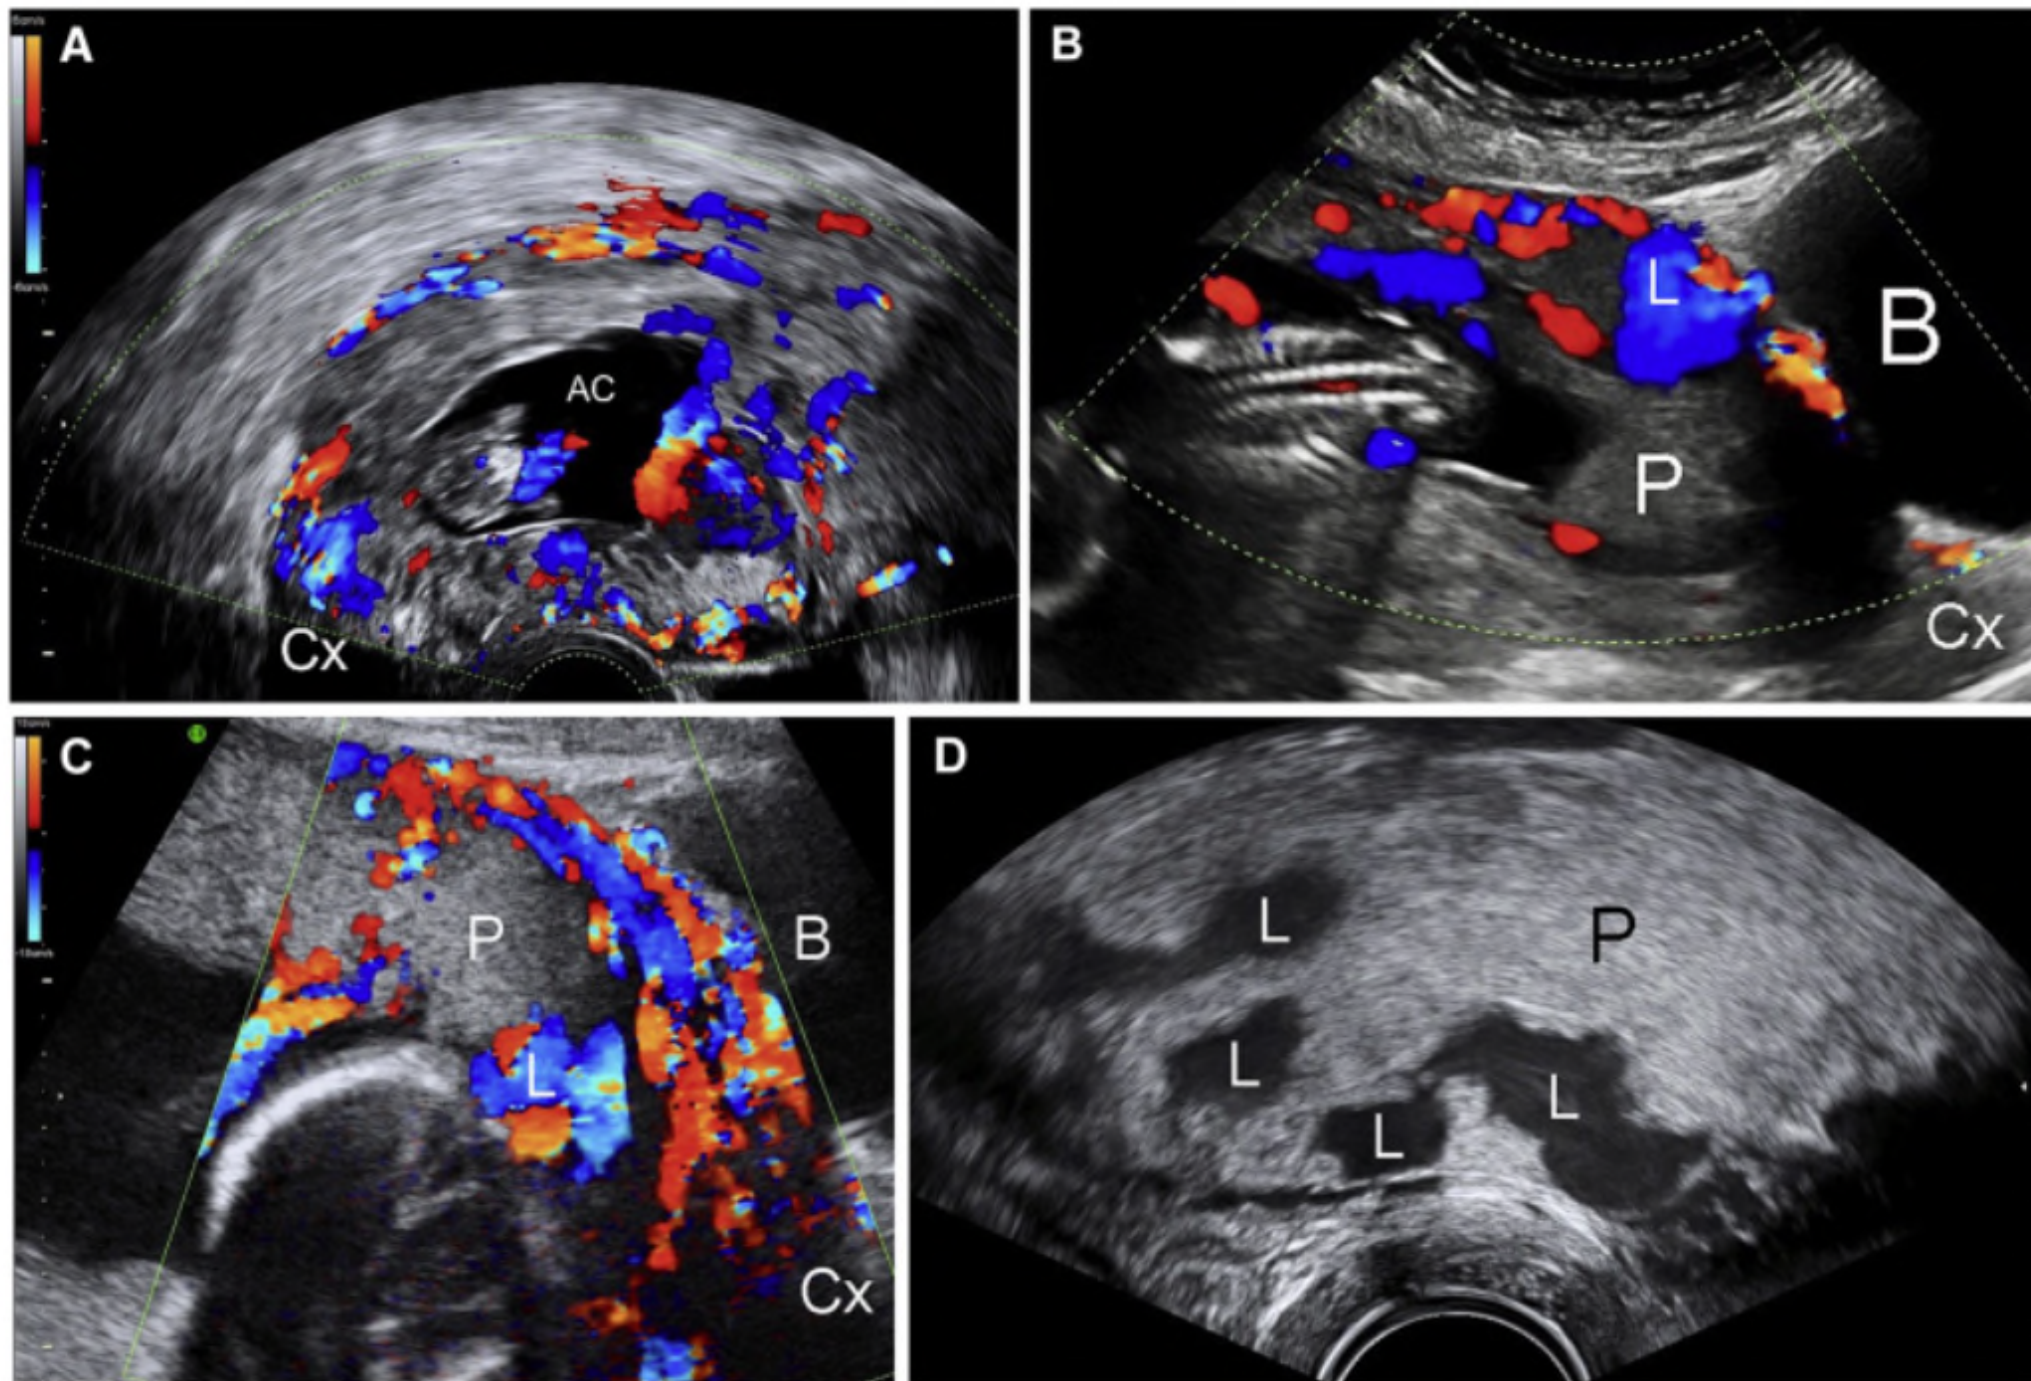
Transvaginal and transabdominal ultrasound views in case of a CSP
